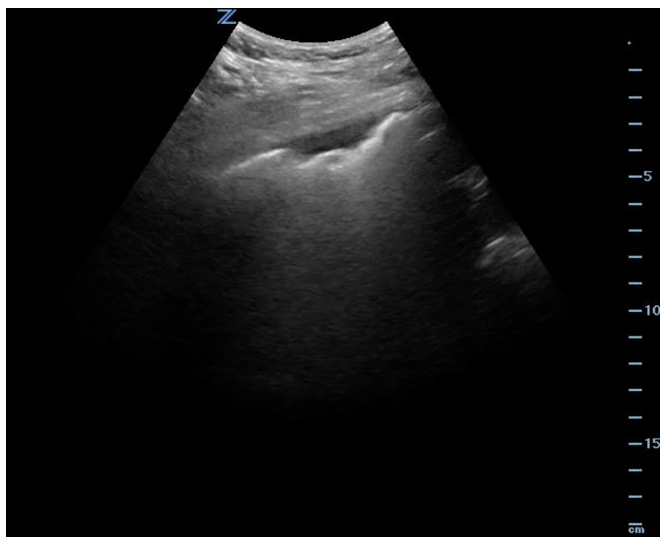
Ultrasound demonstrating an irregular pleural line with a subpleural consolidation in a patient with COVID-19.
